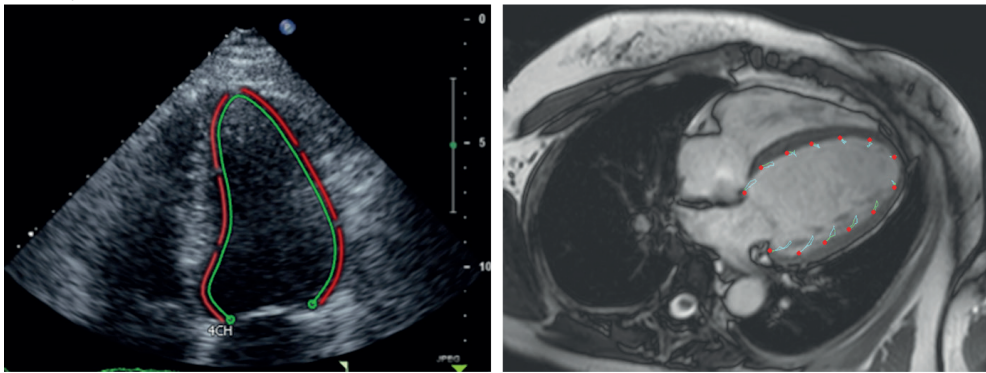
Examples of speckle-tracking echocardiography and cardiac magnetic resonance feature tracking (4-Chamber).
